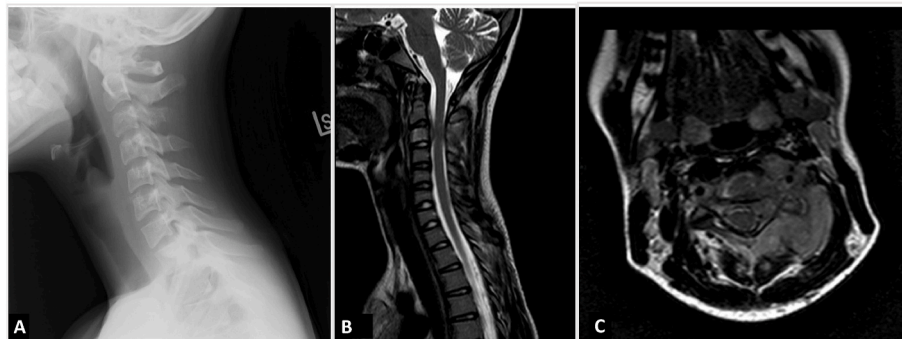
Radiological findings of EWSA of C3 prior to neo-adjuvant chemotherapy: (A) Lateral radiograph (B) MRI sagittal view (C) MRI axial view.
